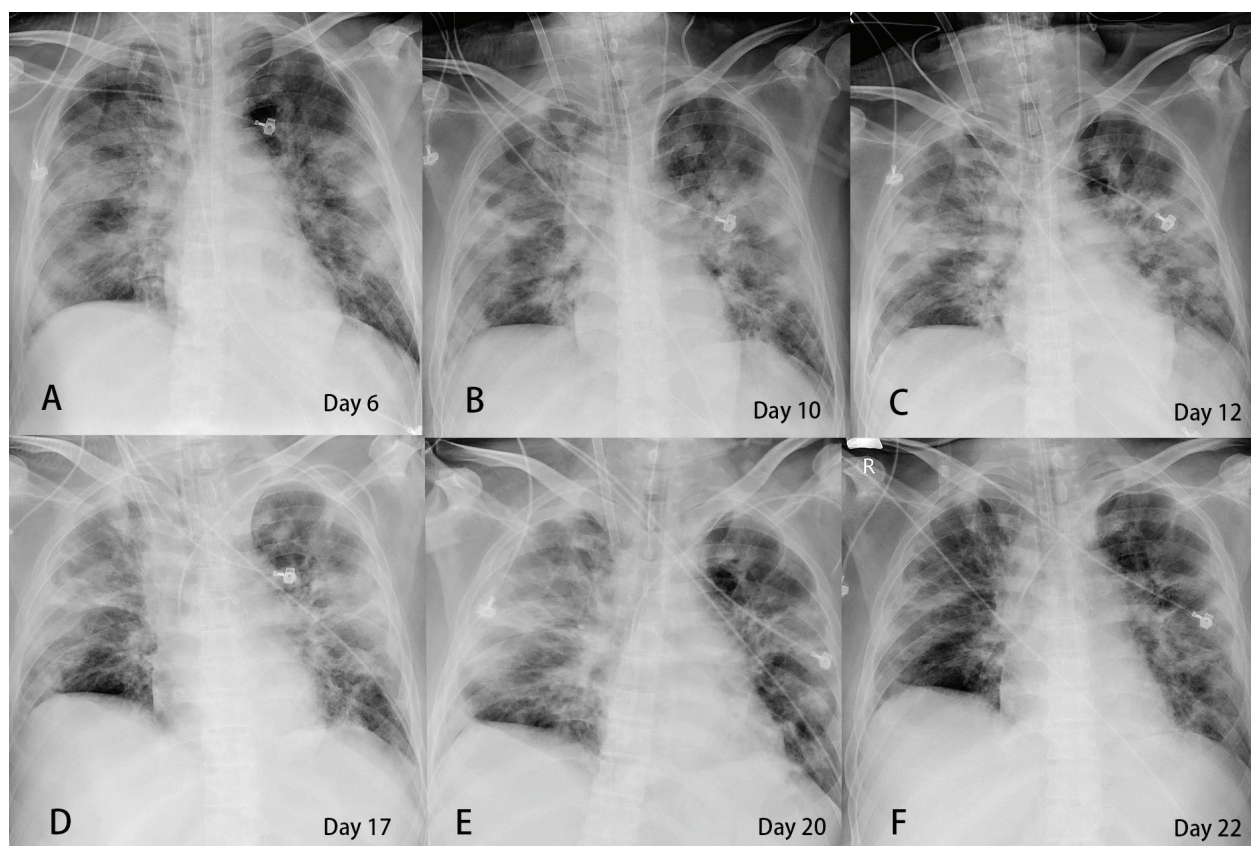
A-F: Serial chest radiography from day 6 to day 22.
